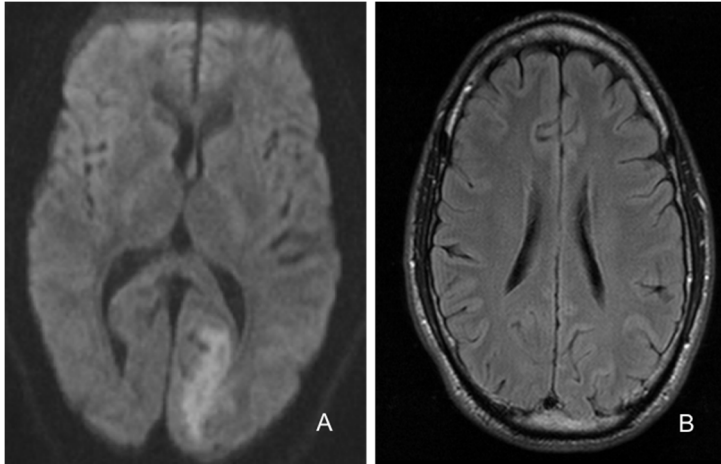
Brain MRI of a 44 year-old male patient with a history of MA, presenting with right homonymous hemianopsia and migraine headache. (A) MRI-DWI on day 3 showing restricted diffusion in the occipital lobe. (B) On follow-up imaging 18 days later there was no visible ischemic lesion.
